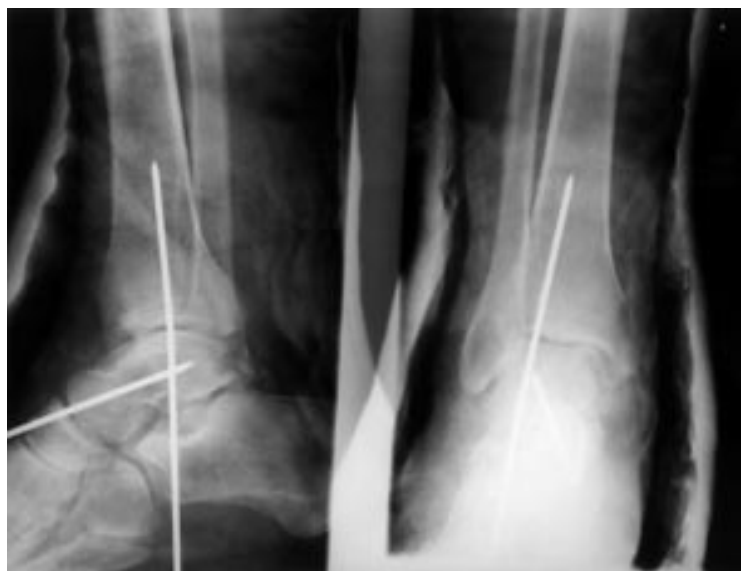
Postoperative anteroposterior and lateral radiographs of the ankle demonstrating the reduction and internal fixation of the talus.
